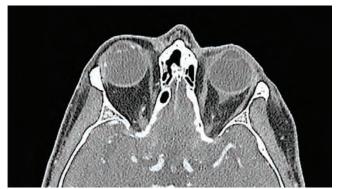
The CT scan revealed the implanted scleral buckle with a somewhat diagonal orientation in the axial plane, but no evidence of associated pre- or post-septal cellulitis.
